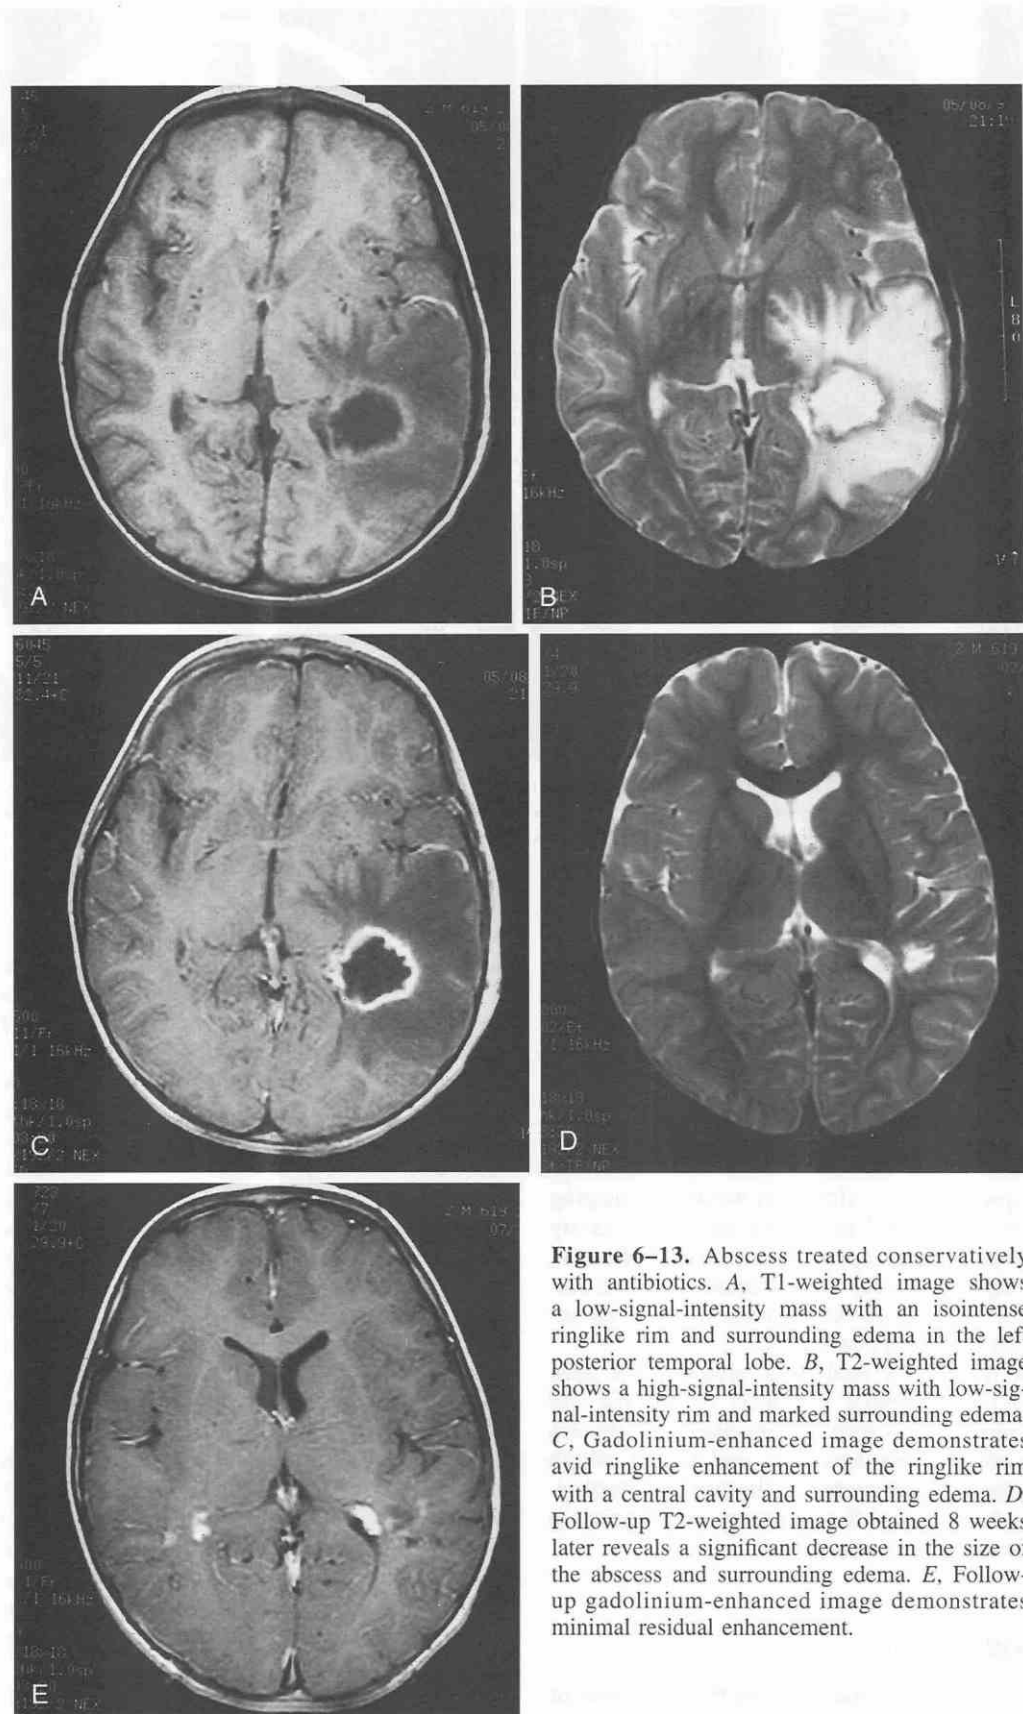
Abscess treated conservatively with antibiotics. *A*, T1-weighted image shows a low-signal-intensity mass with an isointense ringlike rim and surrounding edema in the left posterior temporal lobe. *B*, T2-weighted image shows a high-signal-intensity mass with low-signal-intensity rim and marked surrounding edema. *C*, Gadolinium-enhanced image demonstrates avid ringlike enhancement of the ringlike rim with a central cavity and surrounding edema. *D*, Follow-up T2-weighted image obtained 8 weeks later reveals a significant decrease in the size of the abscess and surrounding edema. *E*, Follow-up gadolinium-enhanced image demonstrates minimal residual enhancement.
